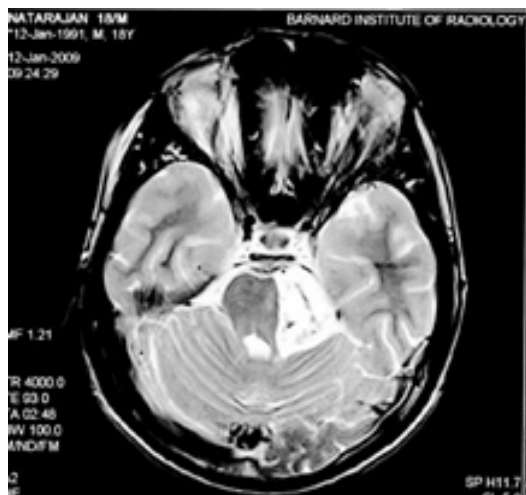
MRI -Epidermoid. Note the density similar to CSF and inhomogeneity within mass
